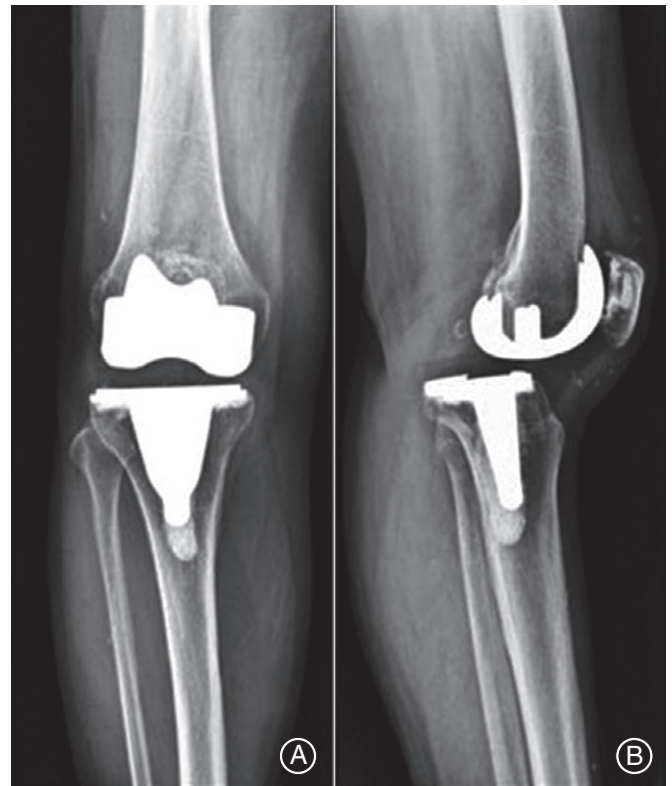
Anterior (A) and lateral (B) radiographs of knee, 2 years after TKA using a traditional cruciate-retaining implant with notable loosening and polyethylene wear of the implant¹².
